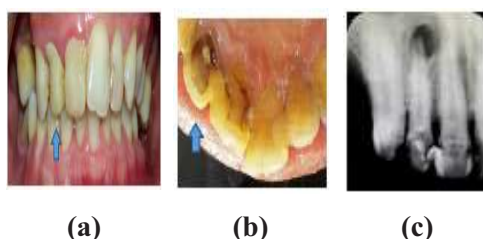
(a) and (b) Preoperative photograph showing tooth 12. (c) Radiograph showing radiolucency involving apex of 12.
